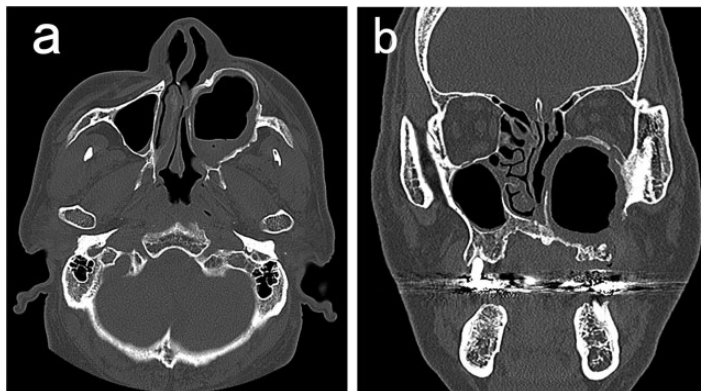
Computed tomography images 3 months after fenestration showing that the volume of the lesion had significantly decreased. (a) Axial view and (b) coronal view.
